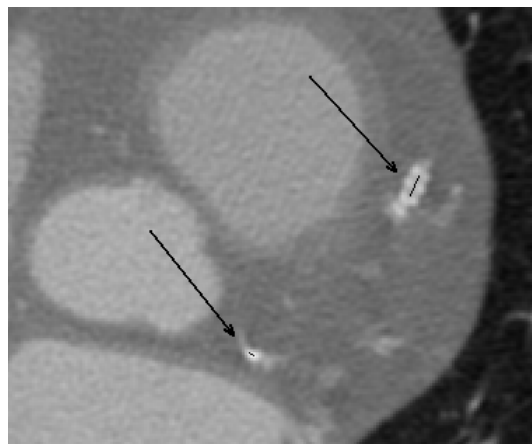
A CTA slice showing the segment of centerline (thin black line) extracted from the calcified portion of the LCX artery (bottom arrow) and the centerline passing through the stent at LAD artery (top arrow).
